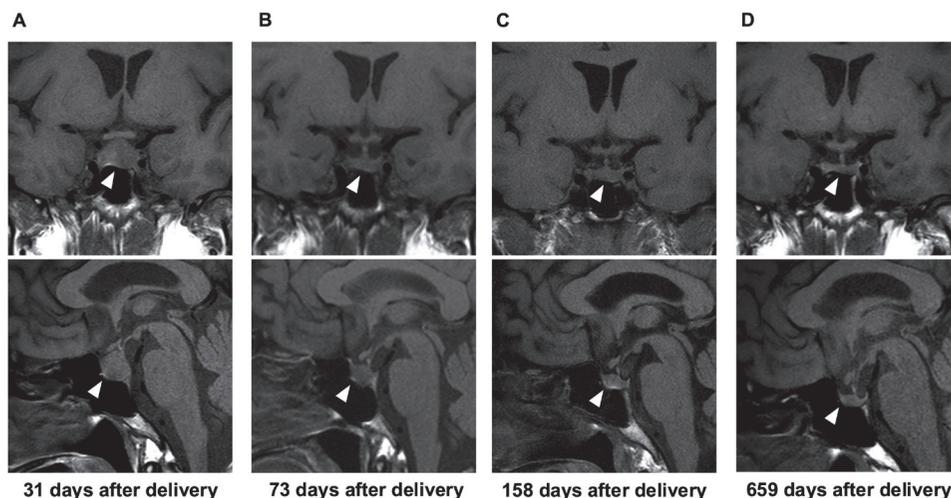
Magnetic resonance imaging (MRI) of the pituitary gland. The upper panel is a coronal cross-sectional image, and the lower panel is a sagittal cross-sectional image. (A) MRI taken when Sheehan syndrome was diagnosed 31 days after delivery. The size of the pituitary gland was $19 \times 14 \times 15$ mm. (B) MRI taken at the endocrine outpatient clinic 73 days after delivery. The size of the pituitary gland was $16 \times 6.5 \times 9.5$ mm. (C) MRI taken at the endocrine outpatient clinic 158 days after delivery. The size of the pituitary gland was $14 \times 7.5 \times 9.5$ mm. (D) MRI taken at the endocrine outpatient clinic 659 days after delivery. The size of the pituitary gland was $14 \times 5.3 \times 9.5$ mm.
